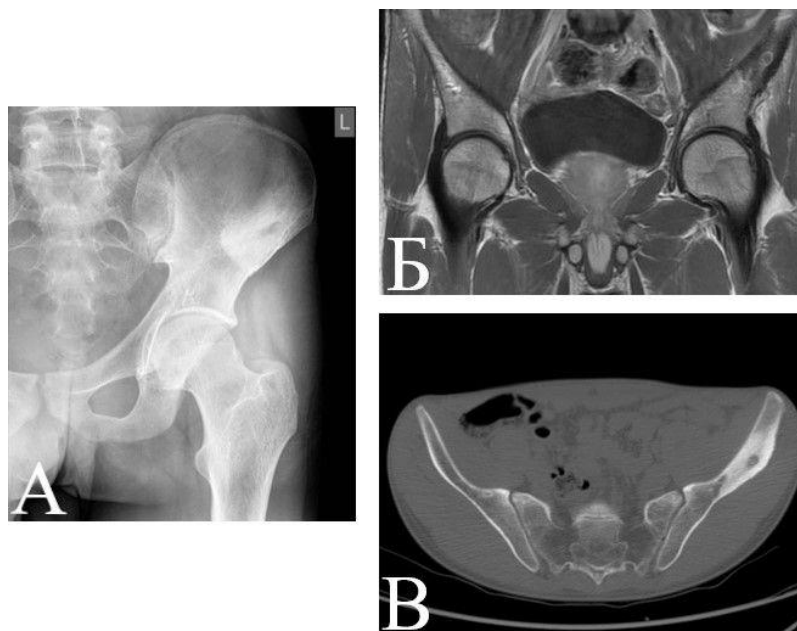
A – Conventional radiograph showing hyperostosis, in the center of which a well-demarcated osteolytic “nidus” lesion is visible. B,C - CT sections that clearly show the exact location of the "nidus".
